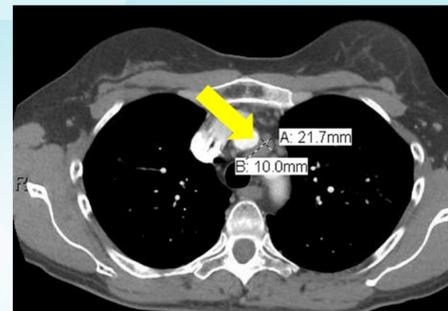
CT of Chest displays multiple levels of hilar lymphadenopathy, with the arrow pointing towards an enlarged node reflective of patient's diagnosis.
